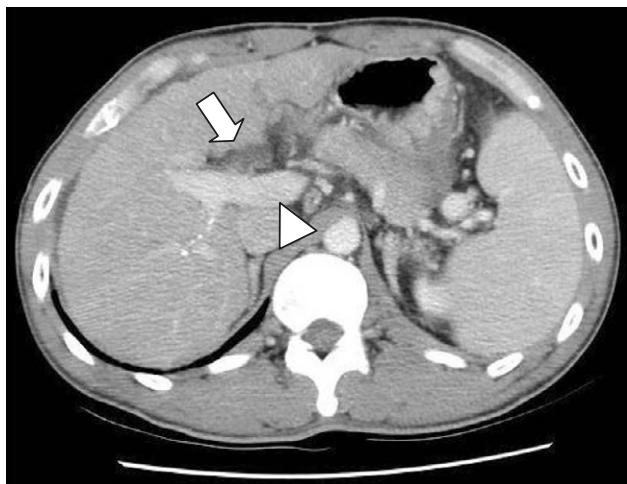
Compared to the previous contrast-enhanced computed tomography, the amount of peripancreatic fluid collection (arrow) around the pancreatic head had decreased, but ascites had slightly increased. The main portal trunk was free of thrombosis (arrowhead).
